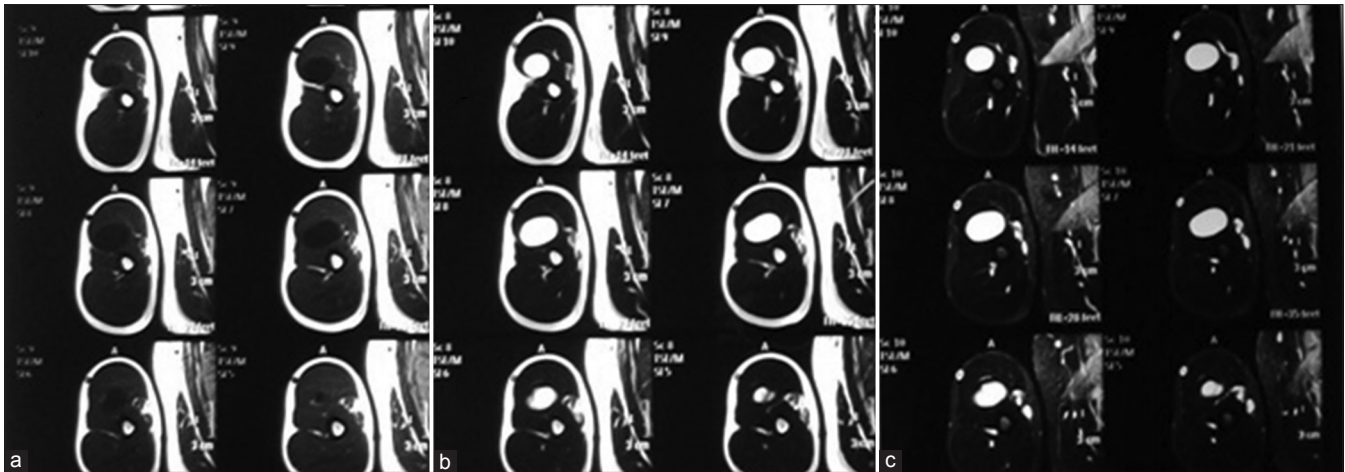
As it is seen in the image, the mass is low signal in T1-weighted sequence (a), high signal in T2-weighted sequence (b), and short inversion time inversion-recovery sequences (c)
